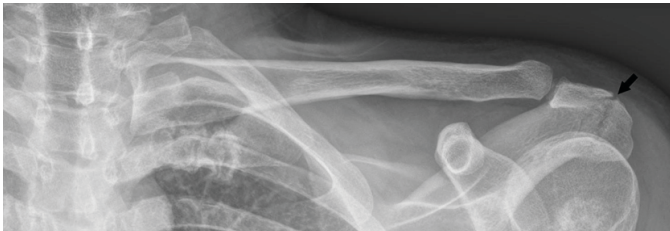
Axial X-ray of acute minimally displaced fracture of the left acromion.
